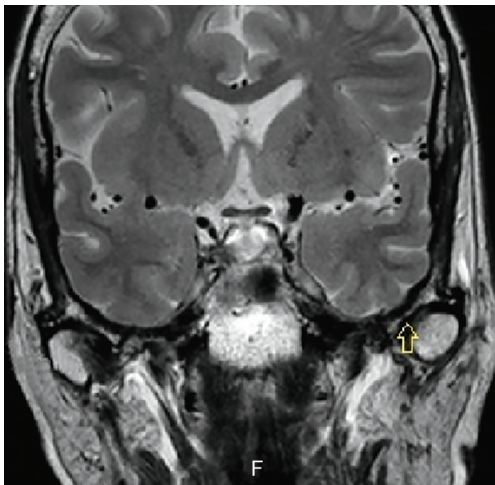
Magnetic resonance image of the TMJ—coronal plane
